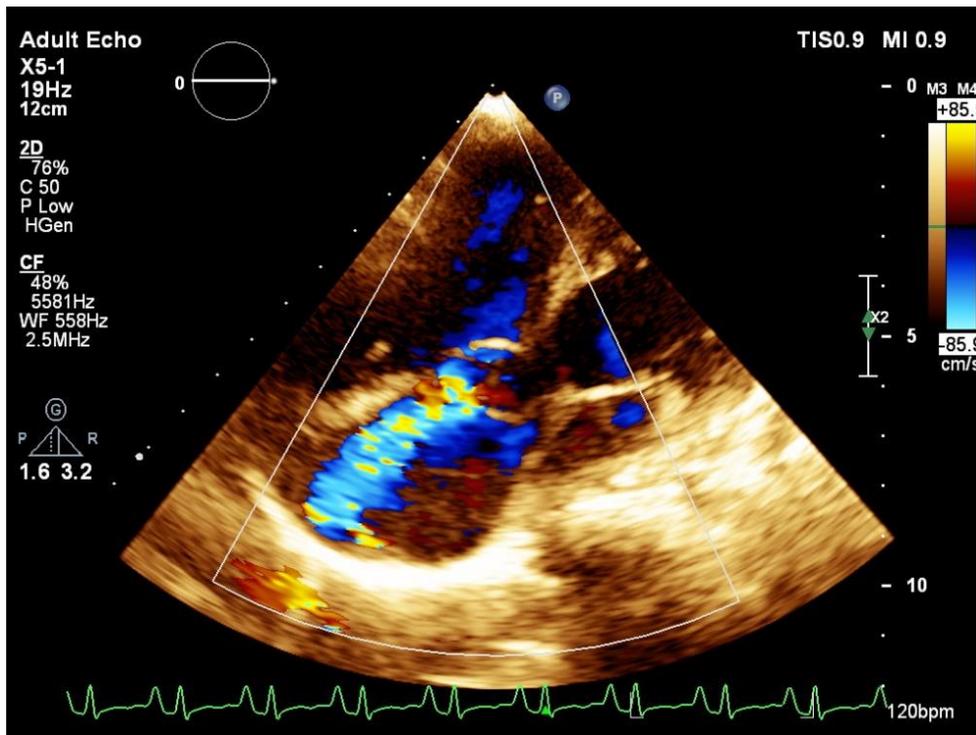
Color echocardiography demonstrating rupture of the sinus of Valsalva into the right atrium
